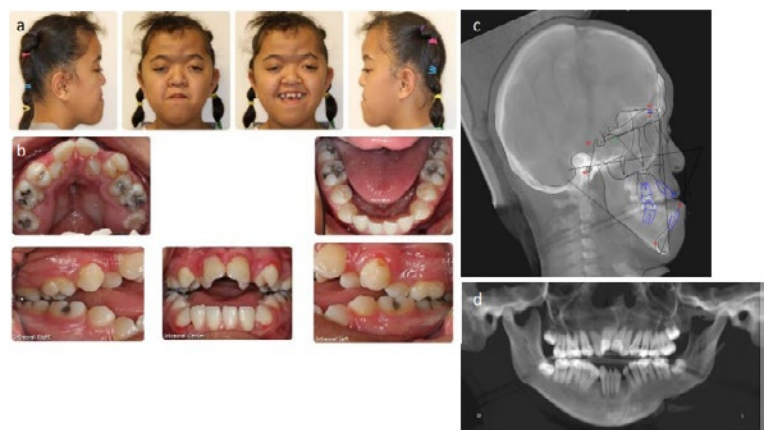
Case 2 - 13-year-old female with Apert syndrome. (a, b) Initial facial photographs and (c, d) radiographs.
